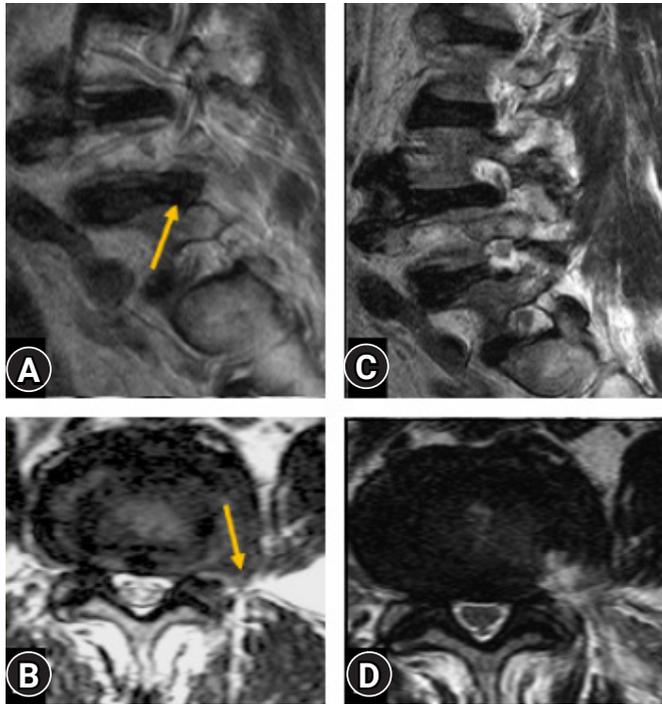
Post-operative confirmatory MRI (C, D) of a case with extra-foraminal disc prolapse (Yellow arrow) (A, B) showing complete decompression and documentation.
